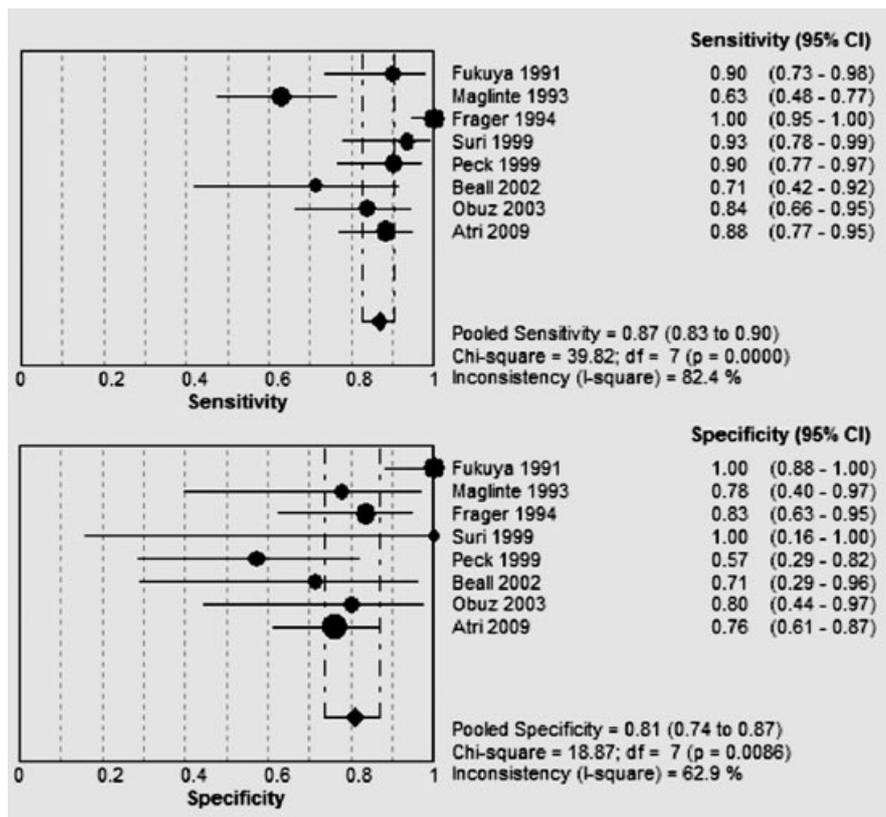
Meta-analysis of studies assessing CT performance for SBO diagnosis (5- to 10-mm slice size). SBO = small bowel obstruction.
